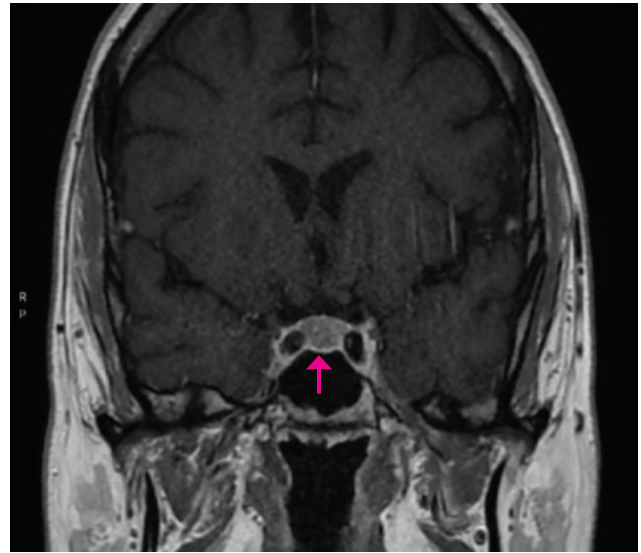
Magnetic resonance imaging of the brain showed a 5-mm pituitary adenoma.
